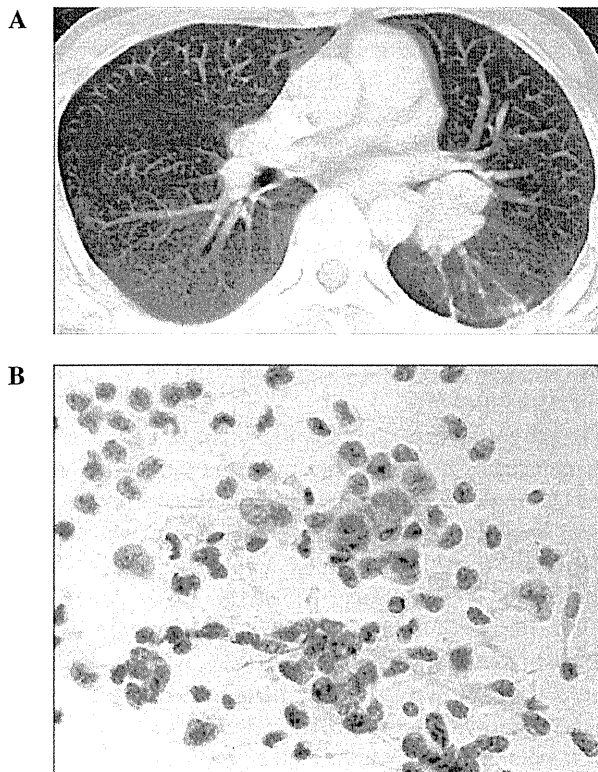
(A) A CT image in November 1996 revealed a 4.5x3.0-cm hilar mass in the left lung. (B) Cytology of the material obtained bronchoscopically from the primary lung tumor revealed SCLC.
